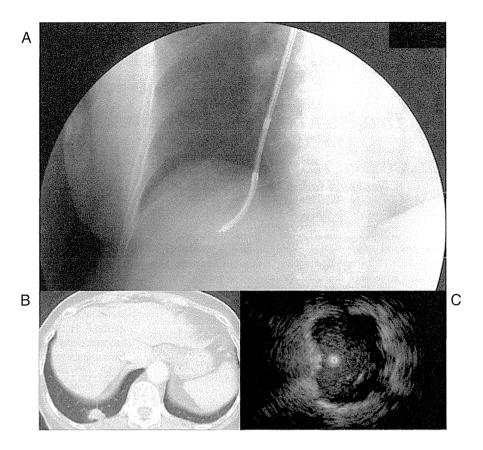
Fluoroscopic image of transbronchial biopsy using a thin bronchoscope (A), computed tomographic image (B), and ultrasonic image of a metastatic colon cancer (adenocarcinoma) examined and diagnosed by endobronchial ultrasound-guided transbronchial biopsy with the thin bronchoscopic method (C).
